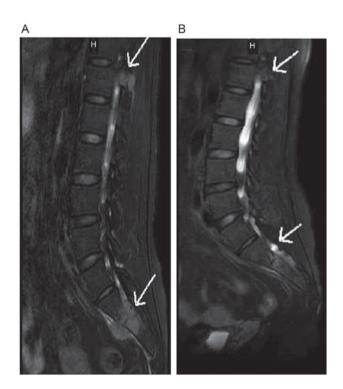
Magnetic resonance imaging of lumbar vertebrae prior to and following lenalidomide therapy. (A) Prior to lenalidomide therapy (11 March 2014). Soft mass and multiple patchy lesions with high attenuations were present in T12 thoracic and L1-L4 lumbar vertebrae. Spine and spinal accessory, S1, S2 and soft tissue surrounding S1 and S2 swelled. (B) Following five cycles of the RCd regimen (26 August 2014). Alleviated swelling of soft tissue surrounding S1 and S2 was present. RCd regimen, lenalidomide at 25 mg on days 1-21, cyclophosphamide at 50 mg on days 1-21 and dexamethasone at 20 mg on days 1, 8, 15 and 22, with 28 days/cycle. The arrow in each of the images point to the plasmacytoma in spine. H, head.
